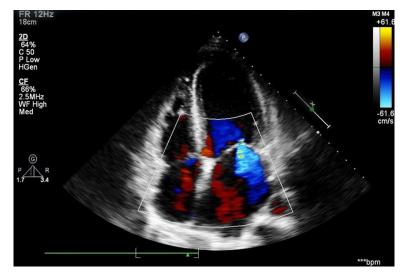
Echocardiography showed moderate mitral and three cusp regurgitation, mild aortic regurgitation, mild aortic valve regurgitation and left ventricular enlargement. Echocardiogram-systolic pulmonary artery pressure (SPAP): 53 mmHg.
